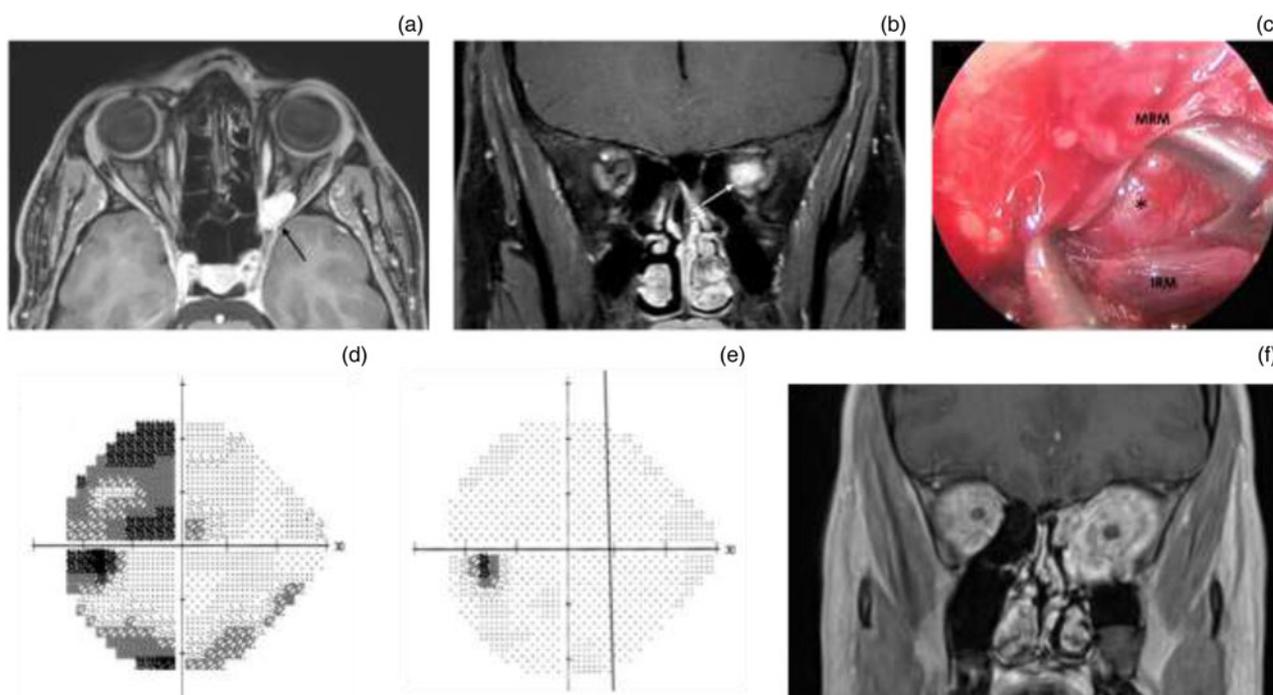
A patient with left orbital apex cavernous haemangioma (patient 3). (a) Pre-operative magnetic resonance image (axial T1-weighted sequence with gadolinium). A black arrow points to the tumour. (b) Pre-operative magnetic resonance image (coronal T1-weighted sequence with gadolinium). A white arrow points to the tumour. (c) Intra-operative endoscopic view. Asterisk indicates the tumour. (d) Pre-operative computerised visual field (greyscale) of the patient's left eye showing the visual field defect. (e) Post-operative computerised visual field of the patient's left eye showing significant improvement. (f) Post-operative magnetic resonance image (coronal T1-weighted sequence with gadolinium), showing orbital fat prolapse into the adjacent paranasal sinuses. MRM = medial rectus muscle; IRM = inferior rectus muscle.
